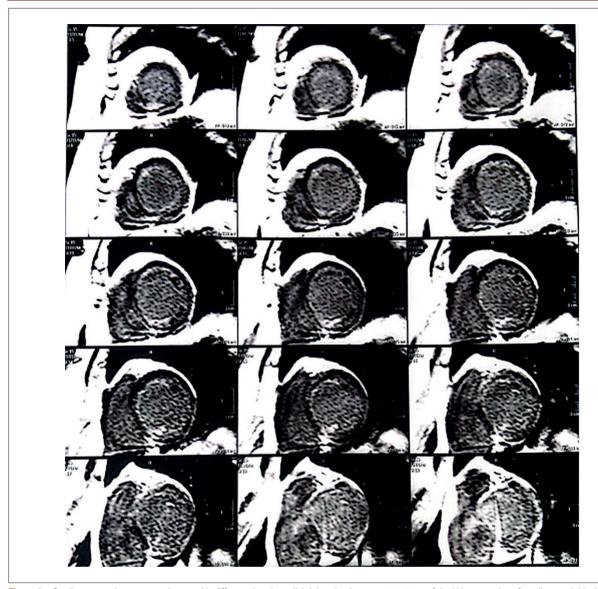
Cardiac magnetic resonance image with diffuse subendocardial delayed enhancement pattern of the LV, suggestive of cardiac amyloidosis.
